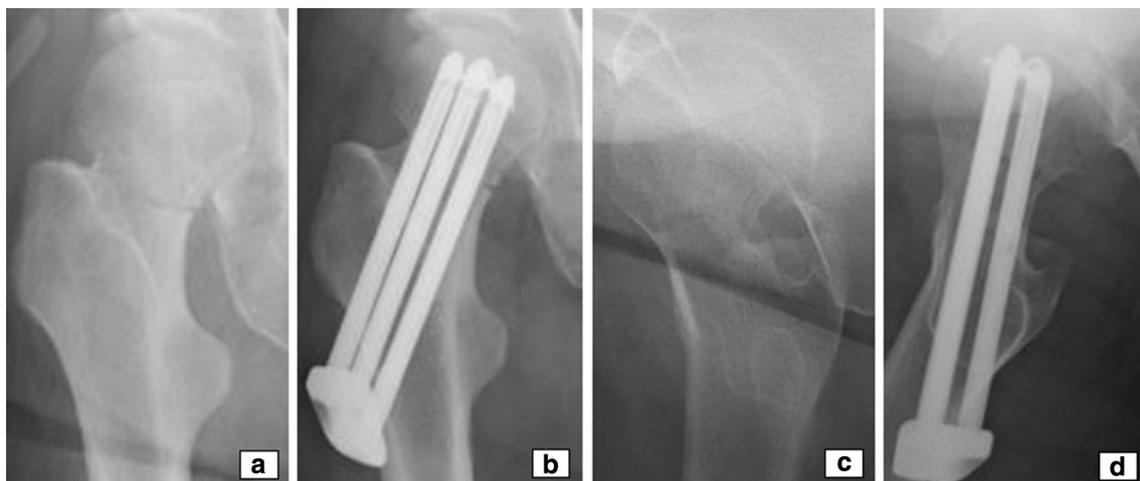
Pre- and postoperative plain radiographs. Retroversion deformity was reduced after the closed reduction
